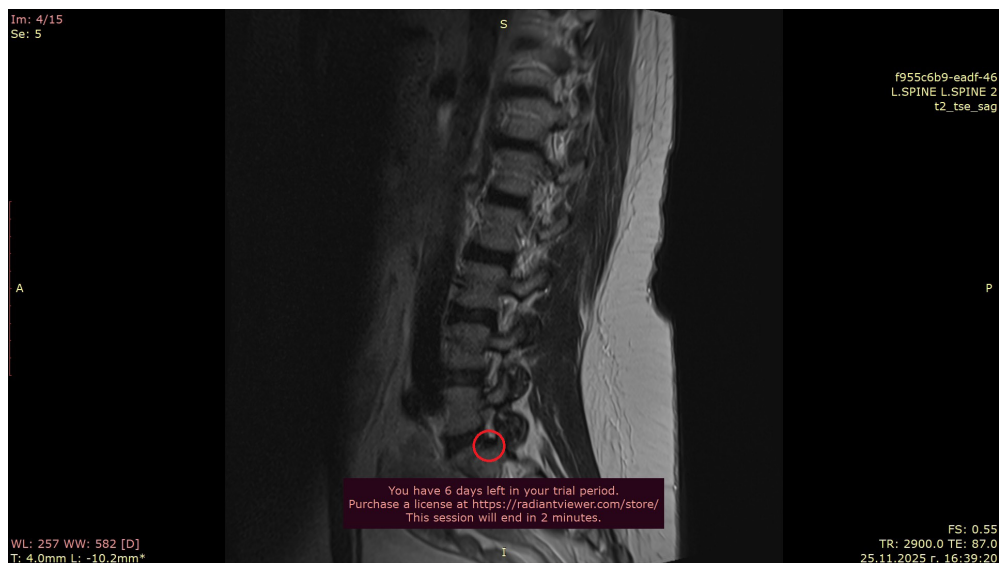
Sagittal T2weighted MRI of the lumbar spine showing degenerative changes and a rightsided paramedian L5–S1 disc herniation with mass effect on the S1 nerve root.
